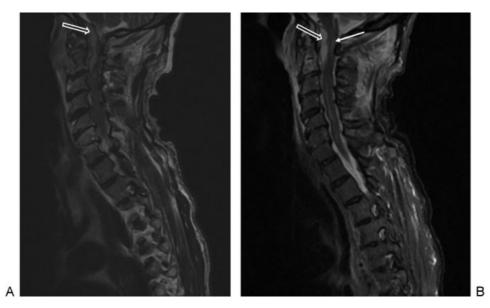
(A) Sagittal T2-weighted magnetic resonance imaging demonstrating epidural abscess posterior the odontoid (arrow). (B) Sagittal short tau inversion recovery sequence demonstrating epidural abscess (open arrow) and spinal cord signal change in the upper cervical spine (closed arrow).
